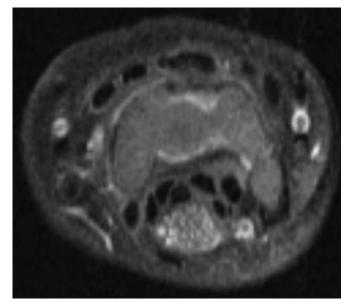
This toddler presented with macrodactyly of the middle finger and was found to have lipomatosis of the median nerve (fibrolipomatous hamartoma) within the carpal tunnel. This entity is known to produce median nerve symptoms and findings, without considering the overgrowth, that may mimic idiopathic carpal tunnel syndrome. T2-weighted fast spin echo image with fat saturation shows an enlarged hyperintense median nerve at the level of the carpal tunnel with fascicles displaced by interdigitating fat. These radiographic features are pathognomonic for lipomatosis of nerve.
